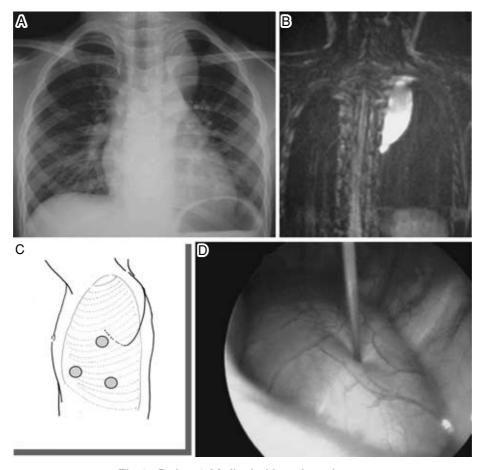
Patient 3. Mediastinal bronchogenic cyst A, preoperative chest radiography; B, preoperative MRI; C, site of trocar ports; D, cystic content was aspirated by fine needle aspiration to decrease cyst.
